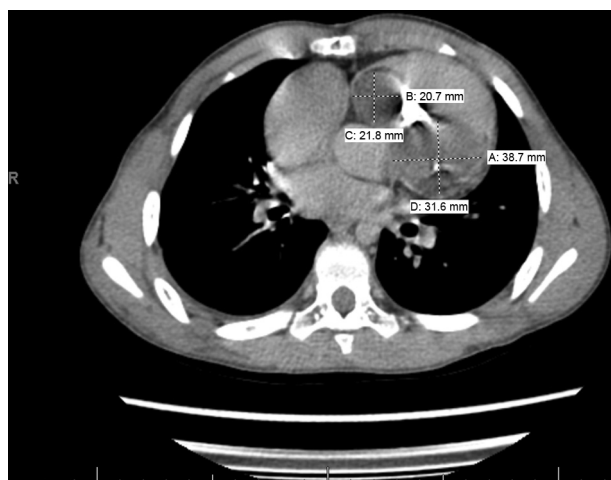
Axial view of computed tomographic image of the chest showing the dimensions of a multicystic mass in the right ventricle.
